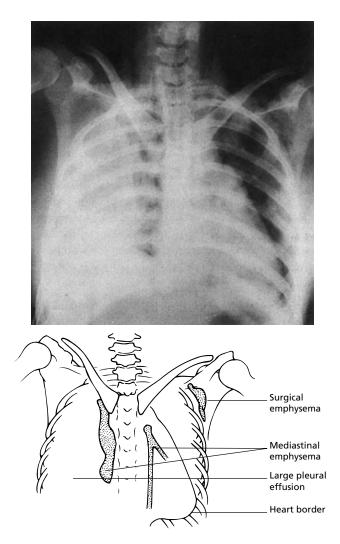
Chest X-ray in oesophageal rupture showing consequences of oesophageal perforation. There is a large right pleural effusion, mediastinal emphysema and gross surgical emphysema in the neck and upper chest wall.
